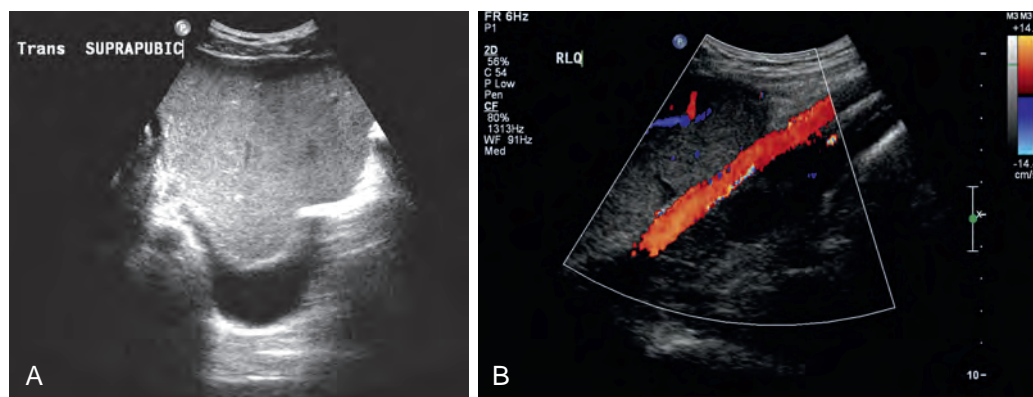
Wandering spleen: sonographic features. A. Transverse ultrasound image of the pelvis shows the spleen overlying the bladder. B. Color Doppler image shows blood flow in the splenic parenchyma adjacent to the iliac artery.
